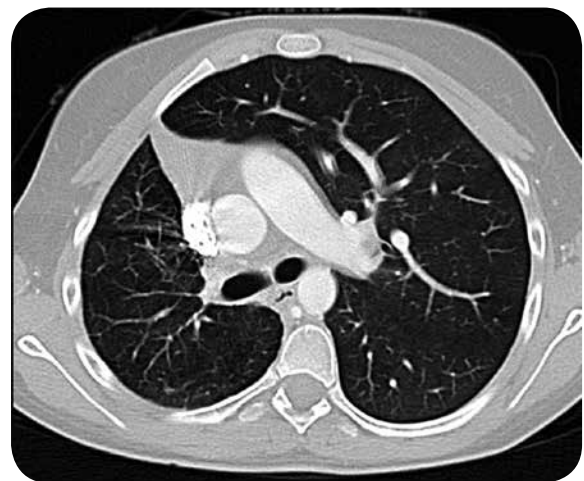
Angio CT, axial, pulmonary window. Decreased right lung volume with deviation of the anterior junction line and visceral space of the mediastinum.
